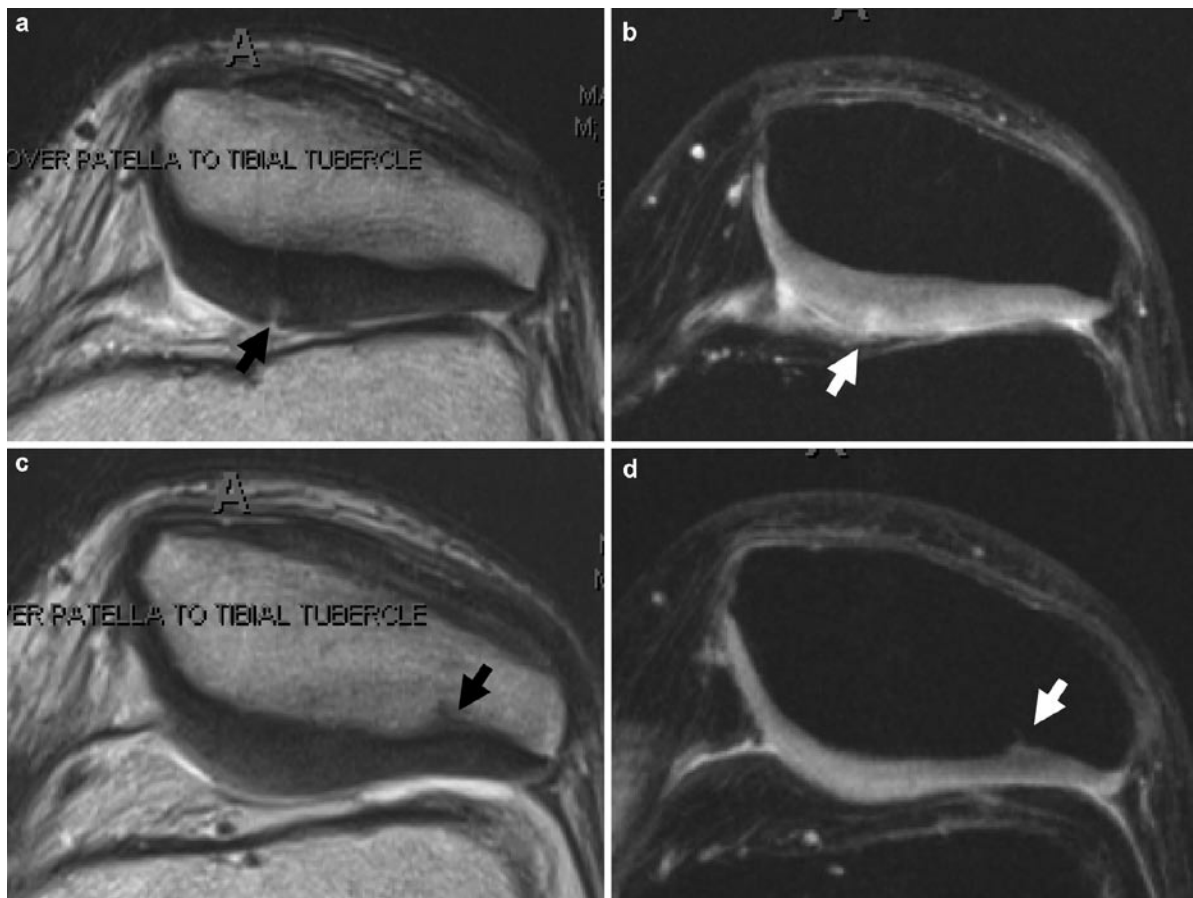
Axial MRI of patient with lateral facet pain and no radiographic joint space narrowing. (a) T2-weighted MRI shows partial thickness chondral defect (arrow). (b) This defect is less well seen on the fat sat image. (c, d) Both techniques show intact
